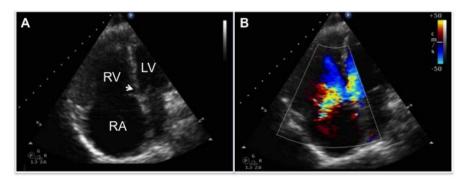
Transthoracic echocardiogram. (A) Apical 4-chamber view, showing dilation of the right atrium and ventricle, interventricular septal defect, and collapse of the left heart chambers due to exacerbated biventricular interdependence. (B) Apical 4-chamber view with color Doppler mode, showing a right-to-left ventricular shunt. LV: left ventricle, RA: right atrium, RV: right ventricle.
